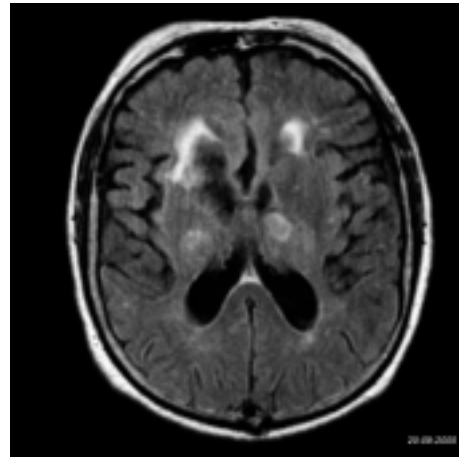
Brain MRI axial FLAIR carried out five days after stroke revealing focal ischemic damage to both thalami and the right putamen.
